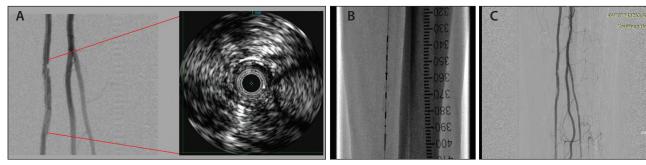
Persistent dissection with slow flow after recanalization of the posterior tibial artery with a 3- X 150-mm uncoated balloon. Intravascular ultrasound revealed a dissection and persistent high-grade stenosis (A). Implantation of two 4-F Tack devices (B). Complete healing of the dissection after Tack implantation with direct inflow and outflow (C).
